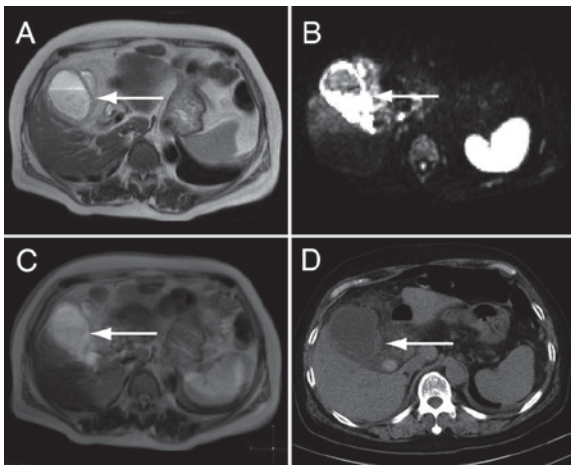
Thickening and high signal intensity in the gallbladder wall of a patient with acute cholecystitis. A 70-year-old woman presented with upper abdominal pain. (A) T2-weighted imaging revealed a thickened gallbladder wall. (B) High signal intensity in the gallbladder wall was observed with DWIBS. (C) The fusion image of T2-weighted imaging and DWIBS showed high signal intensity in the wall of the gallbladder. The high signal intensity with DWIBS indicated inflammation. (D) A thickened gallbladder wall was also observed in computed tomography images. Arrows indicate the gallbladder wall. All the figures were representative of the participants in the present study. DWIBS, diffusion-weighted whole body imaging with background body signal suppression.
